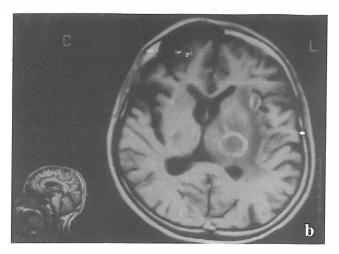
(a-b): Toxoplasmosis ring enhancing lesions; (a) axial and (b) sagittal contrast enhanced T1 weighted MR images show two ring enhancing lesions in basal ganglia and sylvian cortex with marked surrounding edema.
